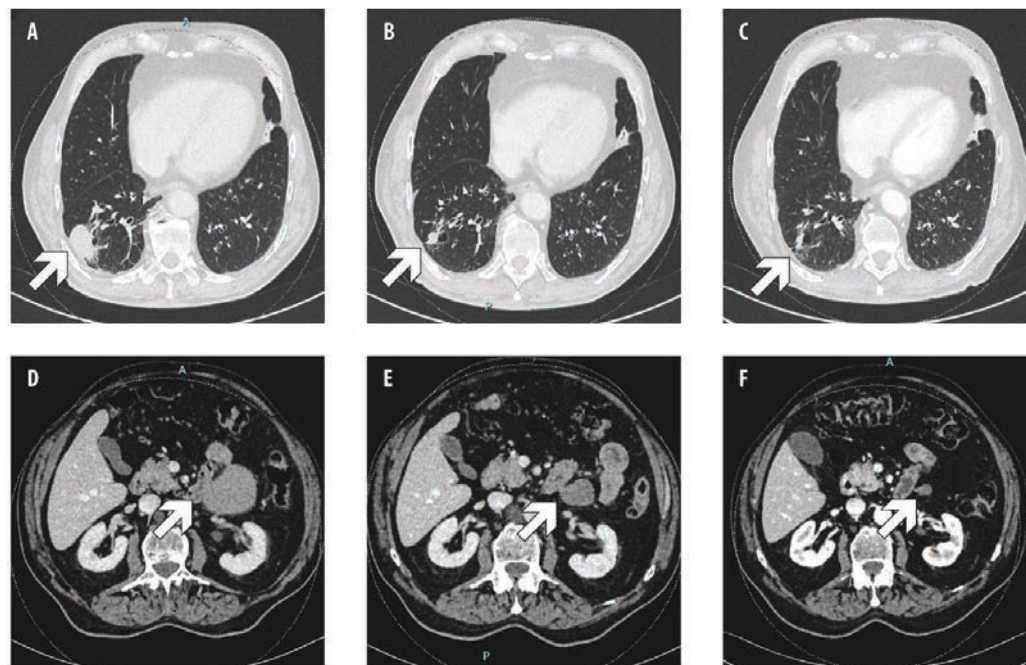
Computed tomography (CT) scan showing, respectively, primary lung tumor and peritoneal metastasis at baseline (A, D), after 12 weeks (B, E) and 1 year (C, F) of tepotinib.
